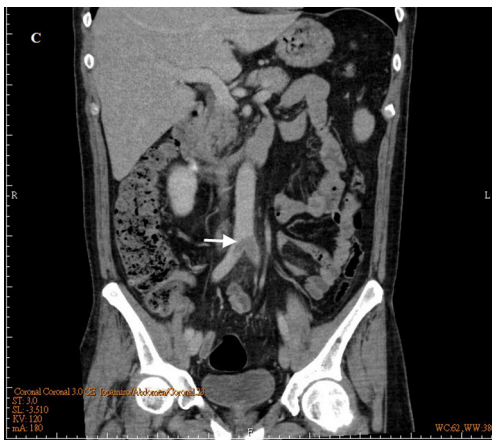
Coronal view of contrast CT showed a huge aortic thrombus at the level of aortic bifurcation (arrow).
